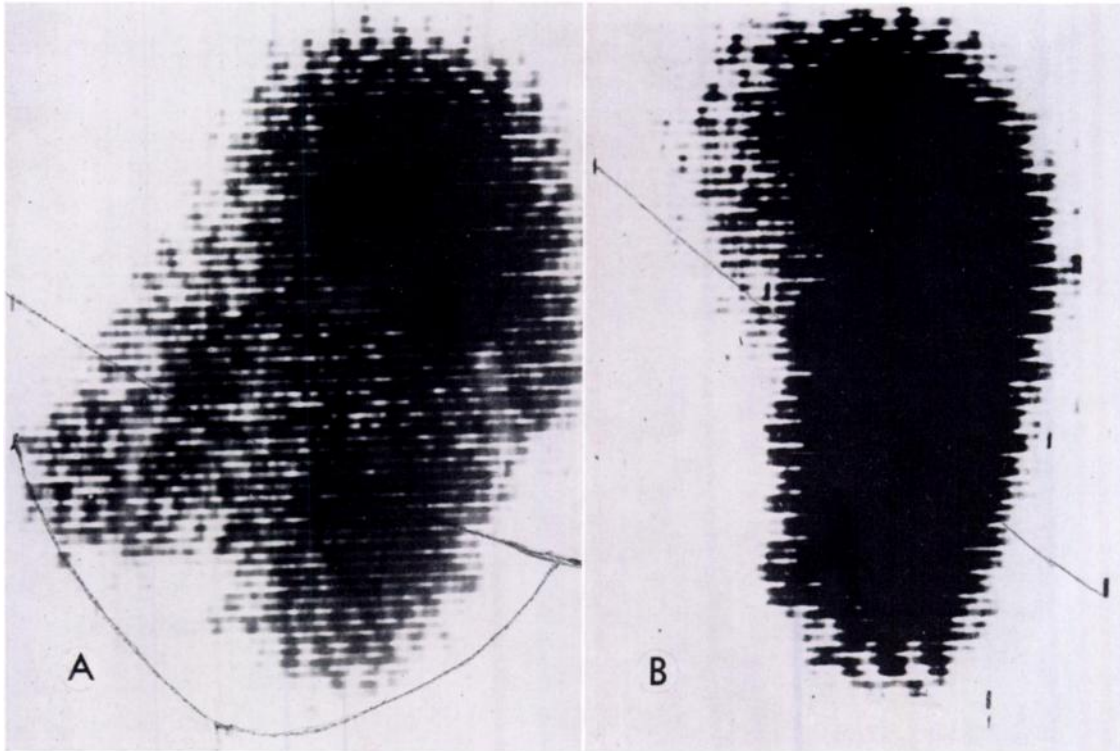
Hodgkin's disease in a 52 year old male. Previously treated with external roentgen-ray therapy to neck and axillary lymph nodes. (A) Scan of an enlarged spleen extending 2 inches below the left costal margin. A well defined comparatively "cold" mass is seen in the region of the hilus of the spleen. (B) Repeat scan immediately after a 12 day course of intravenous endoxan. A considerable reduction in the bulk of the spleen is visible. The comparatively "cold" mass in the region of the hilus has completely disappeared.
